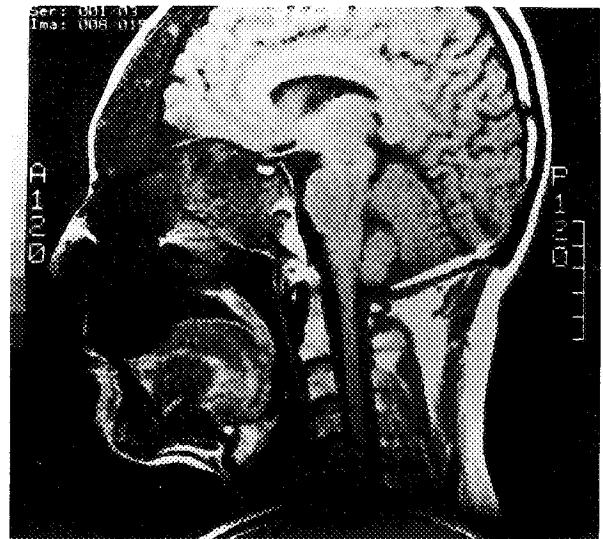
Sagittal section of Patient 1 (T1-weighted image).
